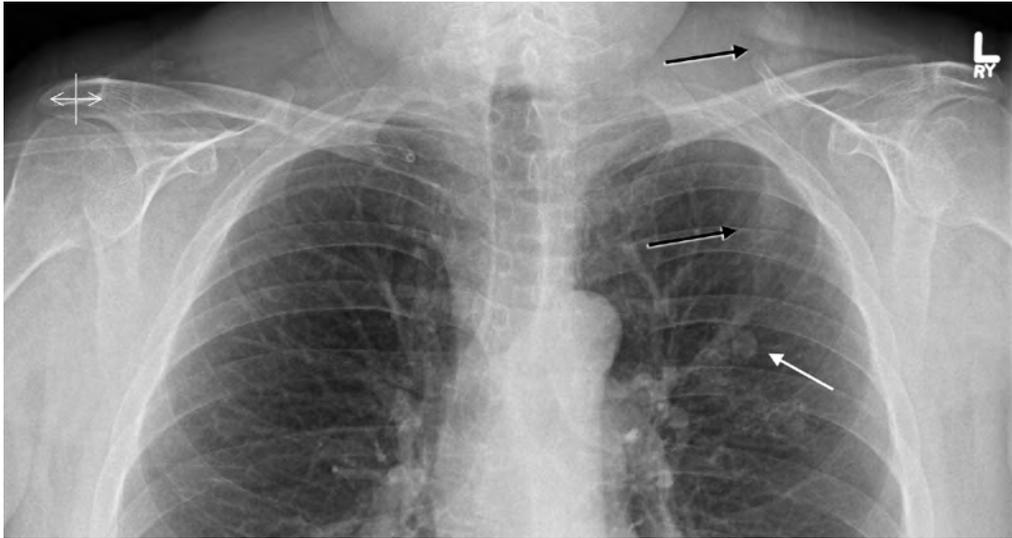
Initial chest radiograph demonstrating SPN. A well-demarcated nodular opacity 10 mm in diameter is well visualized in the left mid-upper lung (white arrow). An oblique, wedge-shaped opacity (black arrows) extends superiorly from this nodule. No other pathology is visualized.
